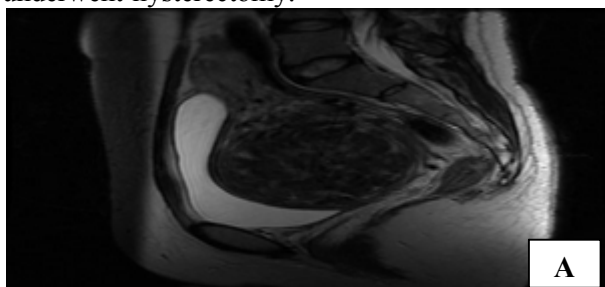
A. Sagittal T2W images show sub-serous sizable fibroid. B. Pelvic angiogram showing both uterine arteries with main supply of fibroid through hypertrophied left uterine artery. C. Selective cannulation of left uterine artery followed by embolization. D. Post uterine artery embolization MRI showing significant volume reduction of fibroid .
